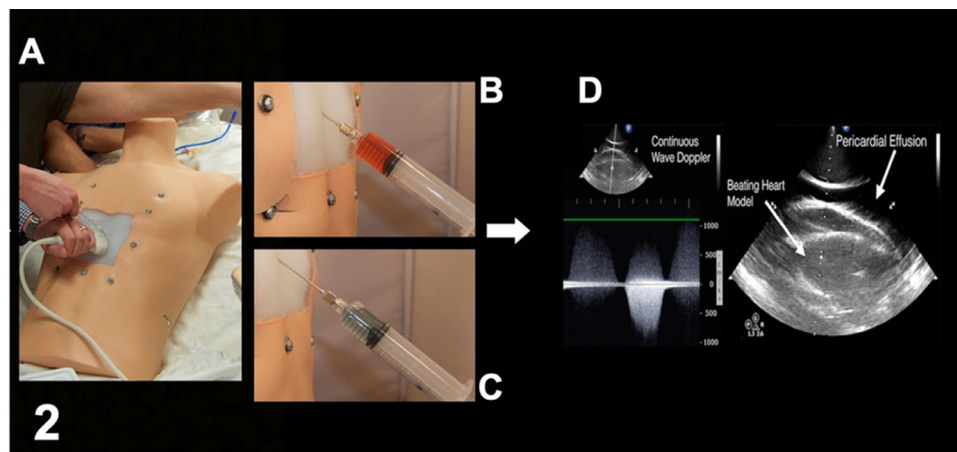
(A) A cardiology fellow training on the model using transthoracic echocardiography in conjunction with the pericardiocentesis kit. (B) A red fluid return signifies incorrect needle placement in the heart. (C) A blue fluid return signifies correct needle placement in the pericardium. (D) A cardiac transthoracic echocardiography probe was used in the subcostal position to acquire the 4-chamber subcostal view to identify pericardial effusion.
